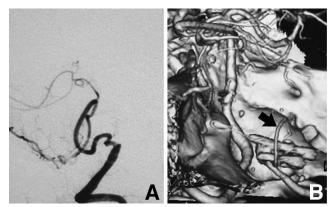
Postoperative right vertebral angiogram (lateral view) (A) and three-dimensional computed tomographic angiogram (B) revealing complete obliteration of the right vertebral artery dissecting aneurysm and good flow in the posterior inferior cerebellar artery (arrow).
